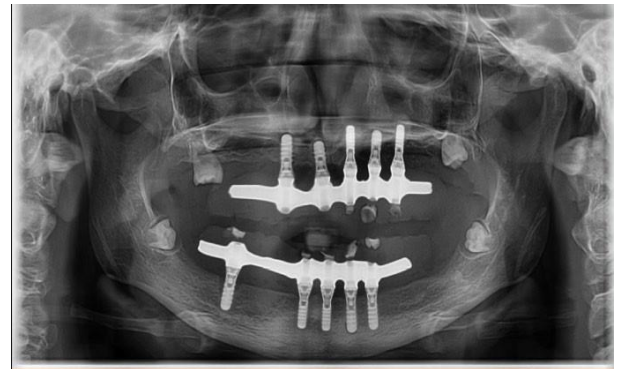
Panoramic x-ray done one year after last surgery; note the absence of any bone loss around upper and lower implants, absence of any abnormal radiolucency, and the perfect fitting of the two hybrid prostheses.
